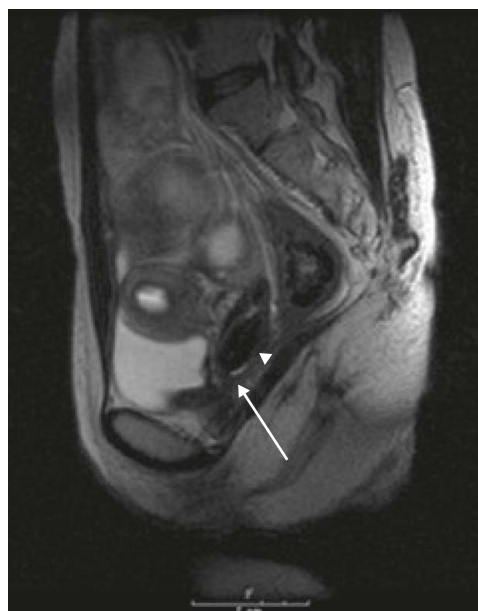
Sagittal T2-weighted image shows minimal fluid, inferior to the stone (arrowhead) and probably superior to the vaginal septum (arrow).
